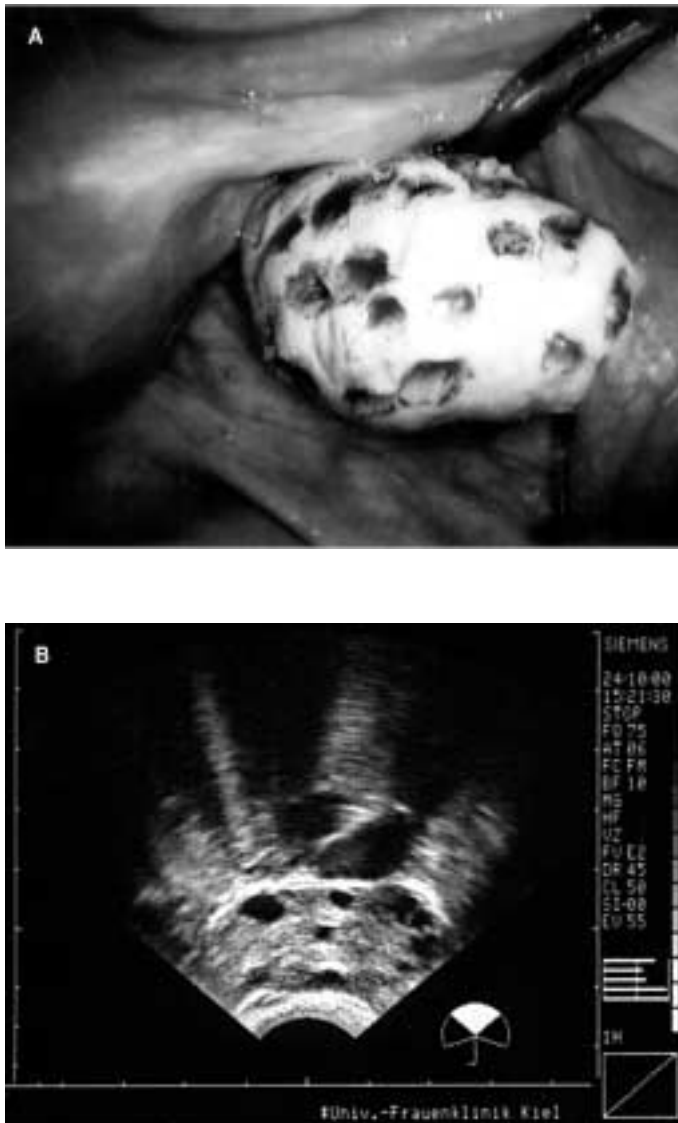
Original ultrasound scan and pelviscopic site of polycystic ovarian syndrome
